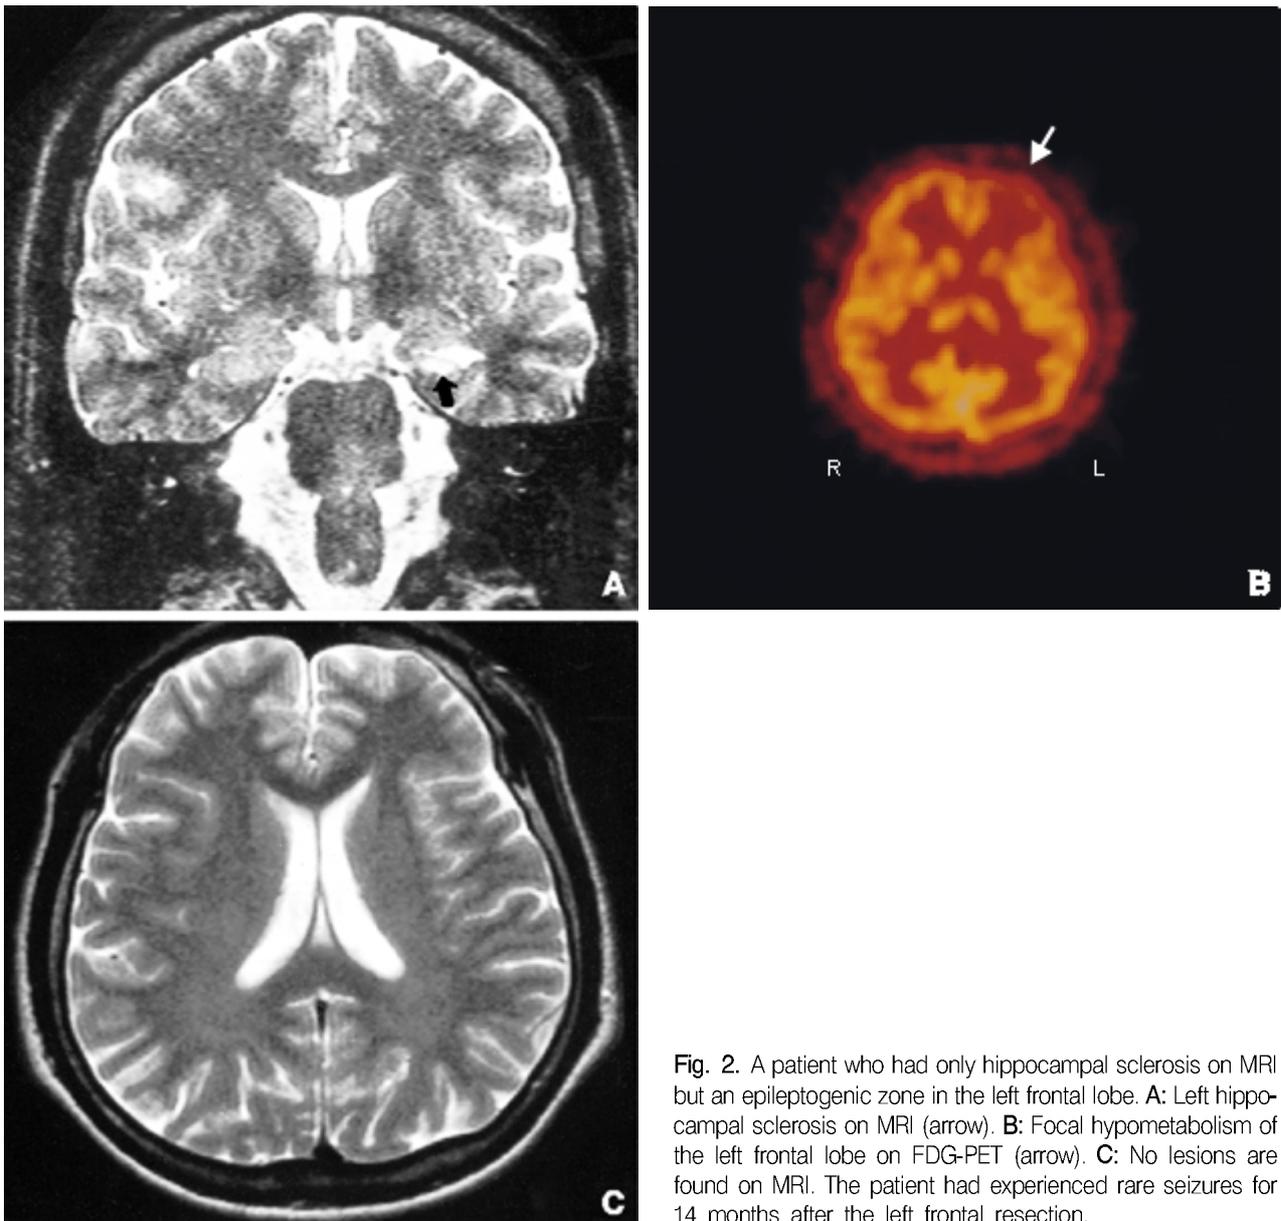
A patient who had only hippocampal sclerosis on MRI but an epileptogenic zone in the left frontal lobe. A: Left hippocampal sclerosis on MRI (arrow). B: Focal hypometabolism of the left frontal lobe on FDG-PET (arrow). C: No lesions are found on MRI. The patient had experienced rare seizures for 14 months after the left frontal resection.
